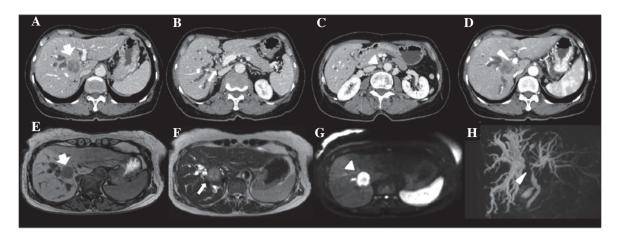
Imaging of intrahepatic biliary tract cancer. A computed tomography scan revealed a 3-cm mass in the 1/8 segment of the liver, resulting in bile duct dilation in both hepatic lobes, enlarged regional lymph nodes and invasion of the PV: (A) Arrow, intrahepatic mass; (B) arrow, enlarged regional lymph nodes; (C) arrowhead, enlarged para-aortic lymph nodes; (D) arrowhead, invasion of the PV. MRI also revealed the intrahepatic mass: (E) T1-weighted image showing a hypointense lesion (arrow) relative to the normal liver; (F) T2-weighted image showing mild hyperintensity (arrow) relative to the liver parenchyma; (G) diffusion-weighted MRI showing high signal intensity (arrowhead); (H) MRCP revealed irregular stricture of the hilar bile duct (arrowhead). PV, portal vein; MRI, magnetic resonance imaging; MRCP, magnetic resonance cholangiopancreatography.
